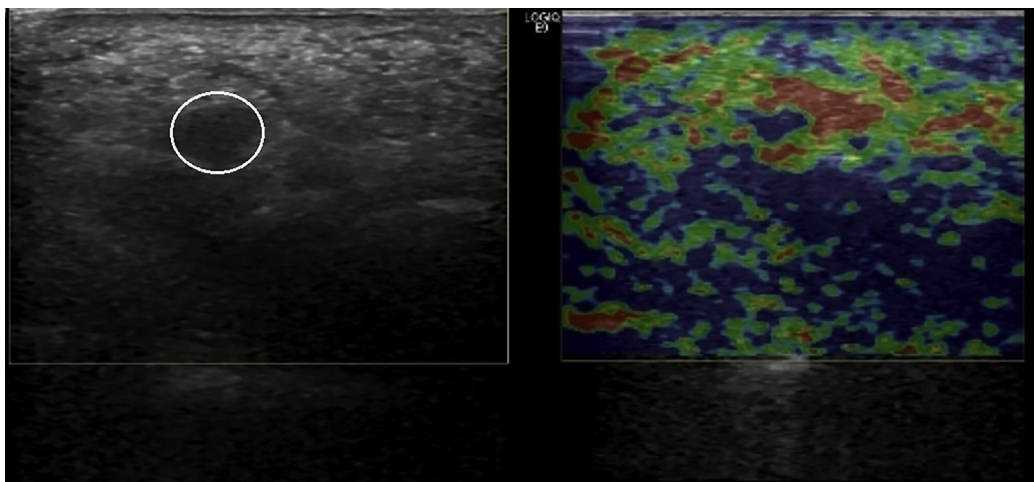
Coronal ultrasound image showing a solid hypoechoic lesion in the third intermetatarsal space of the left foot, consistent with Morton's neuroma. It appears blue on the color map, as seen in long-term cases.
